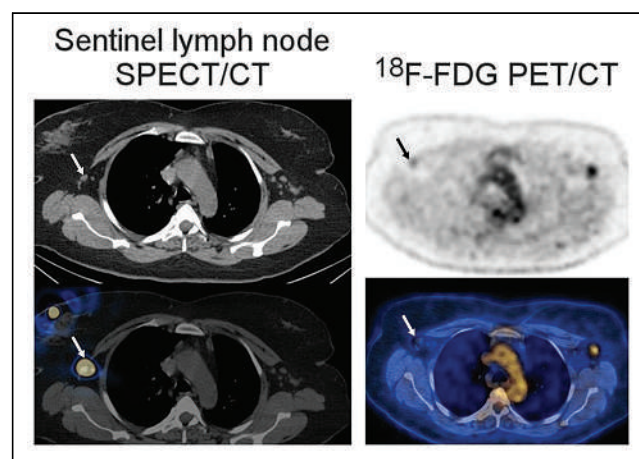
Early metastasis in sentinel lymph node as seen on transaxial SPECT/CT and ^{18}F -FDG PET/CT images of patient with newly diagnosed bilateral invasive lobular breast cancer. SPECT/CT shows right sentinel lymph node (arrows). ^{18}F -FDG PET/CT shows mild uptake in right sentinel lymph node (arrows), found on biopsy to be metastasis. ^{18}F -FDG uptake in left axillary lymph node was also due to metastasis. (Adapted from (38).)
